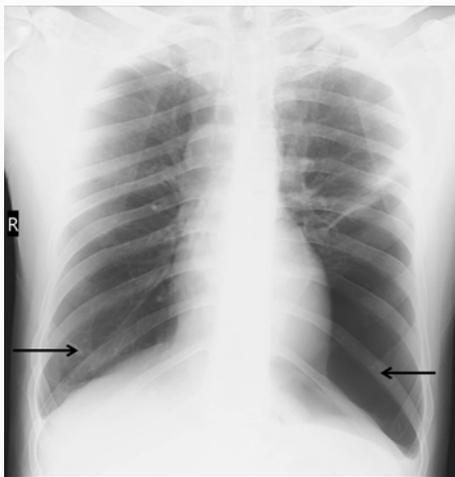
AP chest radiograph of 47-year-old male, known case of bullous emphysema. Note the large emphysematous bullae bilateral lower zones with paucity of bronchovascular markings (arrows). Although patient had no CXR manifestation of COVID pneumonia, he had prolonged hospitalization with supplemental oxygen administration.
